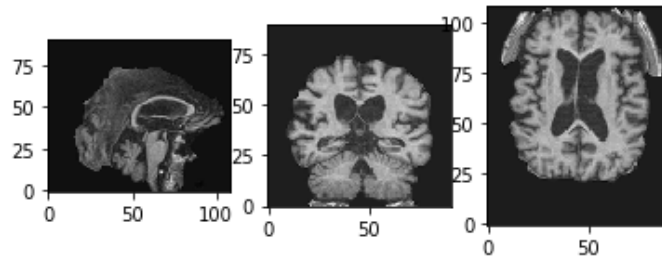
Center slices of a resampled MRI scan from an AD patient.
